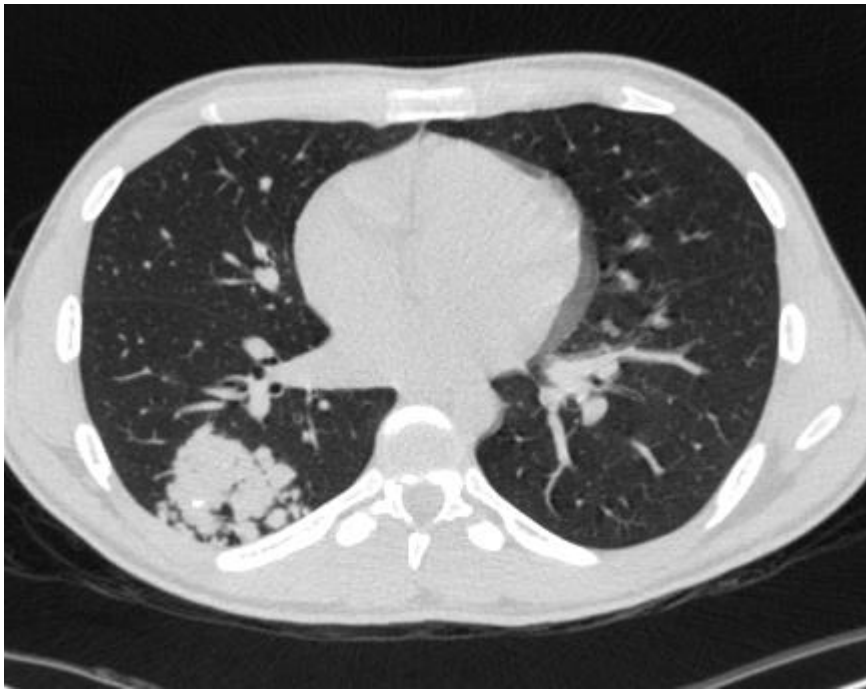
CT thorax demonstrating right lower lobe lung mass. CT guided biopsy revealed a benign pulmonary sclerosing pneumocytoma.
